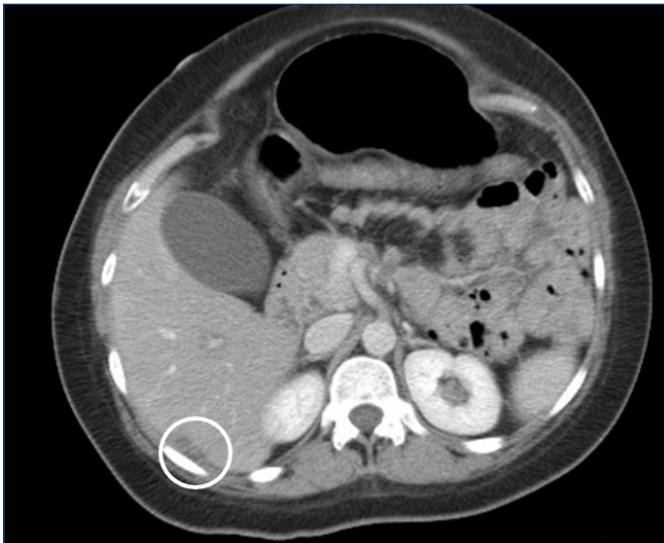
Initial CT on admission demonstrating a $2.3 \times 0.9 \times 2.5$ cm right subcapsular hepatic hematoma (circle).
